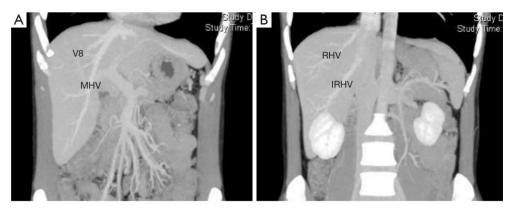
Donor CT angiography showing (A) an MHV-dominant right liver with a significant V8, and (B) a relatively small RHV. CT, computed tomography; MHV, middle hepatic vein; RHV, right hepatic vein; IRHV, inferior right hepatic vein.
